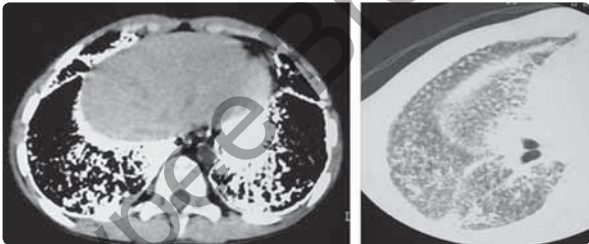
CT-thorax of elder brother mediastinal window and lung window showing the dense nodules of alveolar microlithiasis involving fissure lines
